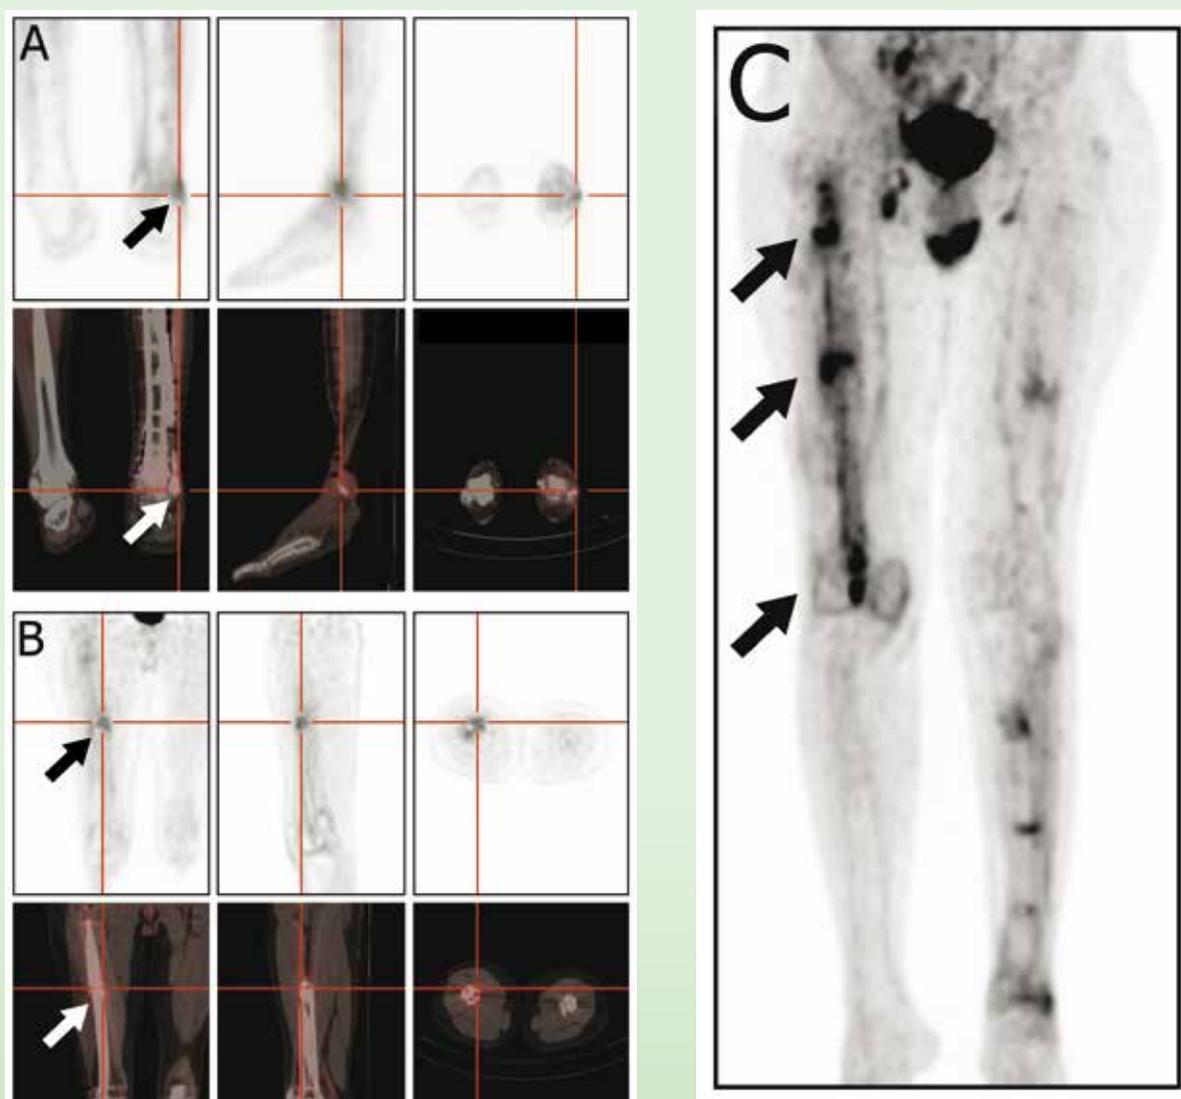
Five months after the trauma, the  $^{18}F$ -FDG PET of the left tibia showed no deep infection. Uptake of FDG was seen in the soft-tissue / vascularised flap but no osseous FDG uptake was demonstrated (panel A, arrow). 3B: The PET/CT of the right femur shows uptake of FDG at the fracture site and intramedullary at the proximal femur (arrow). At this point of time, the patient had no complaints about his right leg which was fully weight bearing. Due to the fact that it was unclear whether FDG uptake at this stage of the fracture healing was physiological or due to ongoing chronic osteomyelitis, no surgical interventions took place. 3C: After seven months, the PET/CT showed increased FDG-uptake at the fracture site but also extension to the proximal and distal intramedullary canal (arrows), indicating an ongoing osteomyelitis. A maximum intensity projection (MIP) is displayed. In this case,  $^{18}F$ -FDG PET/CT demonstrated its potential role in early diagnostics for osteomyelitis.
